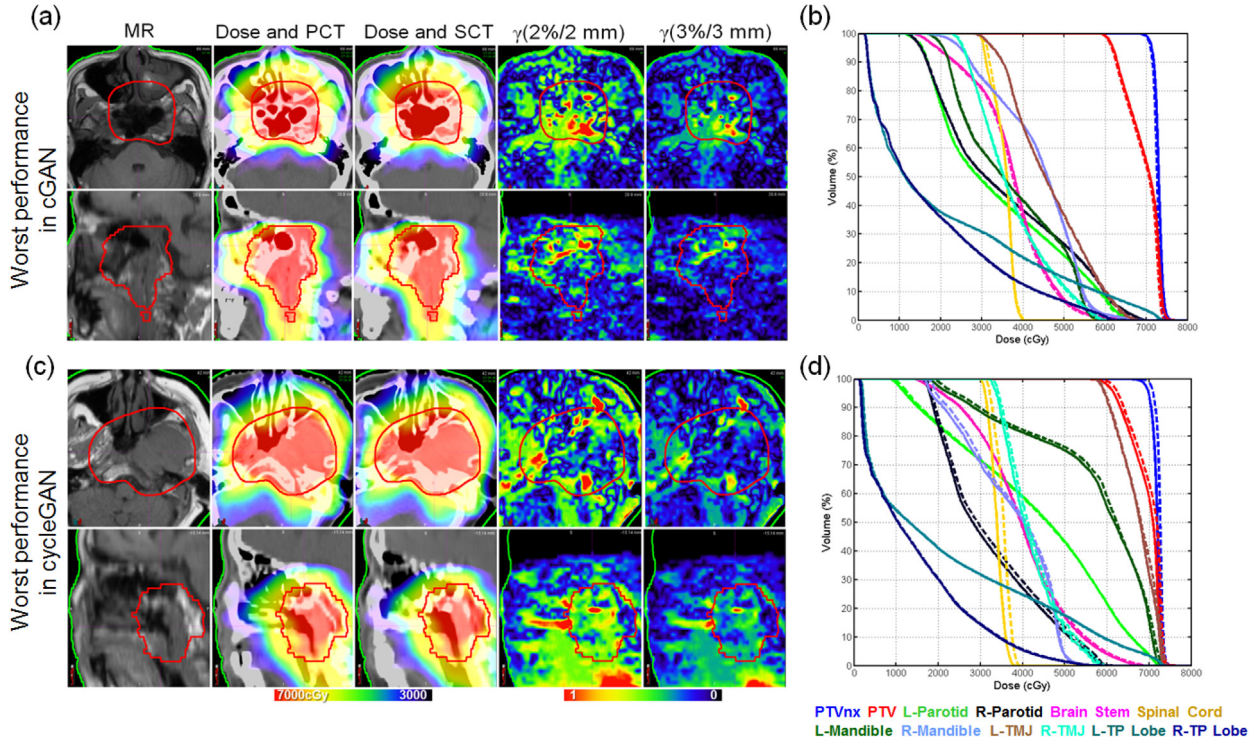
Worst case on dosimetric accuracy in the cGAN-generated SCT images (3 mm/3% γ passing rate = 98.78%) (a) and its DVH (b). Worst case in cycleGAN-generated SCT images (3 mm/3% γ passing rate = 98.55%) (c) and its DVH (d). Abbreviations: cGAN = conditional generative adversarial network; cycleGAN = cycle-consistent generative adversarial network; DVH = dose-volume histogram; SCT = synthetic CT; PTVnx: planning target volume of primary disease, PTV: planning target volume (the red contours in (a) and (c)); TMJ: temporomandibular joint, TP lobe: temporal lobe. L: left, R: right.
